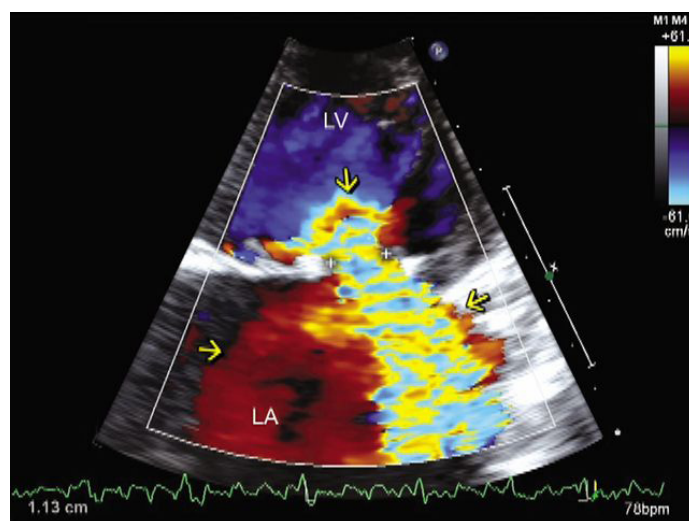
Two-dimensional transthoracic echocardiography in apical four-chamber view in a patient with severe MR. The vertical arrow points to a large flow acceleration, and the distance between the two + signs represents the vena contracta width, which measures 1.13 cm, indicative of severe MR. Not only the turbulent flow signals (right arrow in LA) but also the accompanying laminar flow signals (red, left arrow in LA) moving in the same phase as the turbulent flow signals represent MR. Thus, MR flow signals practically completely fill the LA, indicative of torrential MR. MR severity would have been underestimated if the red laminar signals were not taken into account. LV: left ventricle; LA: left atrium; MR: mitral regurgitation. Reproduced with permission from Manjunath *et al.*^[4]
